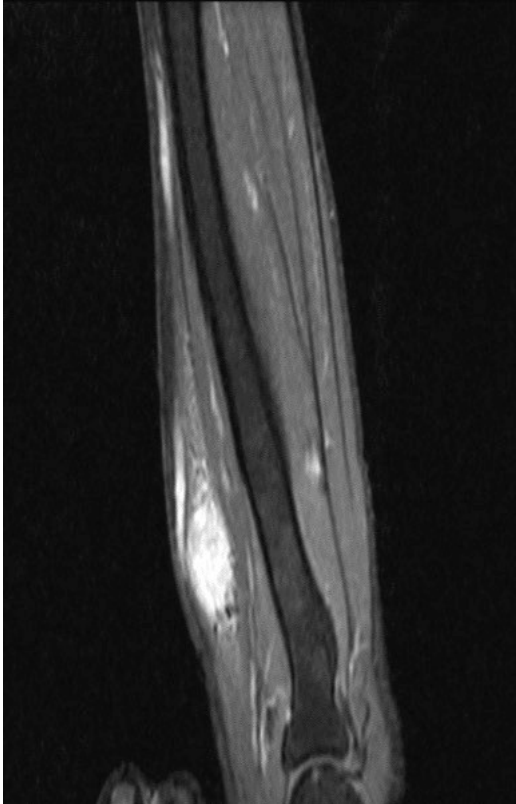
A hypervascular fusiform-shaped solid tumour demonstrated by MRI
